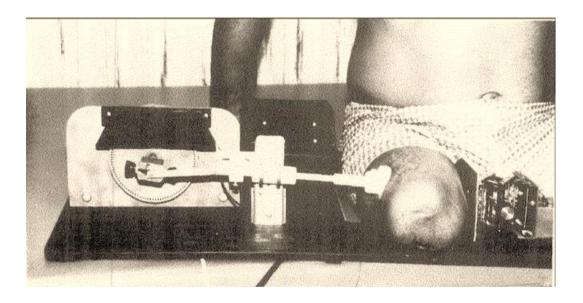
Historic pulsed Doppler system that was useful in characterizing the mechanical properties of soft tissue.
